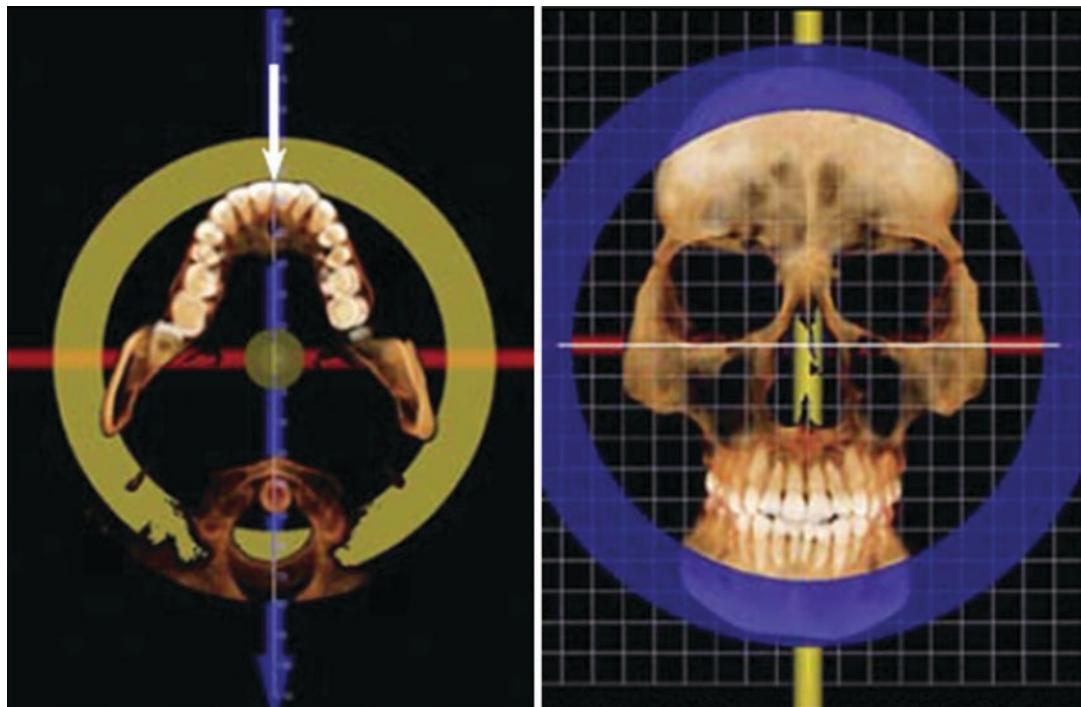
Reorientation of CBCT for asymmetry analysis using axial and frontal views (Reproduced with permission from J Clin Orthod)
